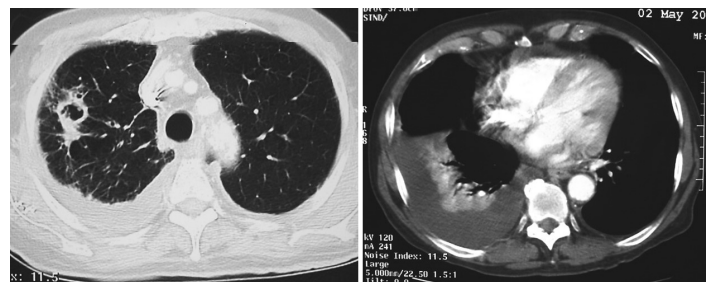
Chest computed tomography of the first admission showing a right pleural effusion and a pulmonary cavity in the right lung
